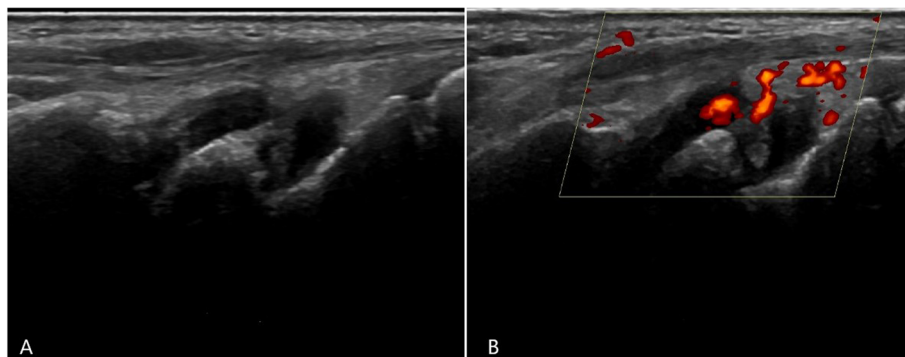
Active synovitis in greyscale (a) and power Doppler (b) MSUS in 50 years old rheumatoid arthritis patient with increased albumin-dNLR score. MSUS, musculoskeletal ultrasound; dNLR, derived neutrophil-to-lymphocyte ratio
